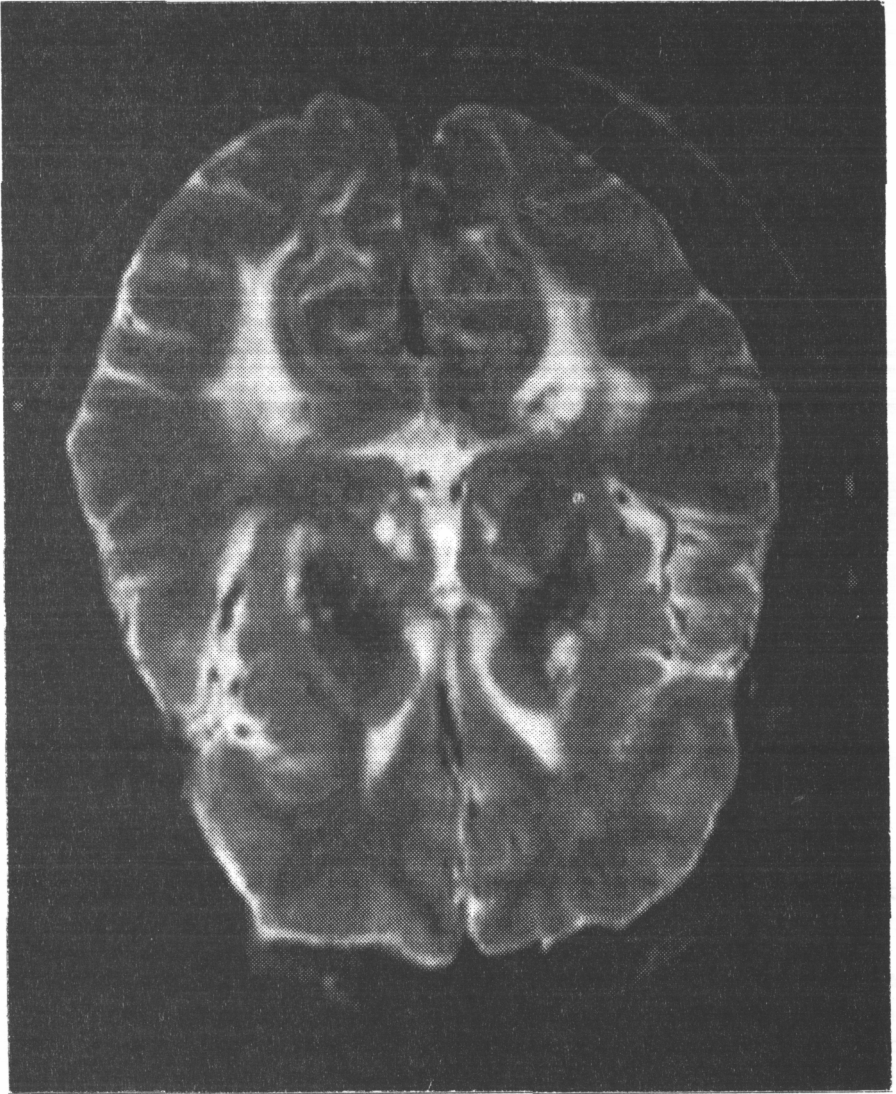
This T2-weighted MRI scan demonstrates multiple ischemic infarctions in the corona radiata, thalamus, and basal ganglia.*
